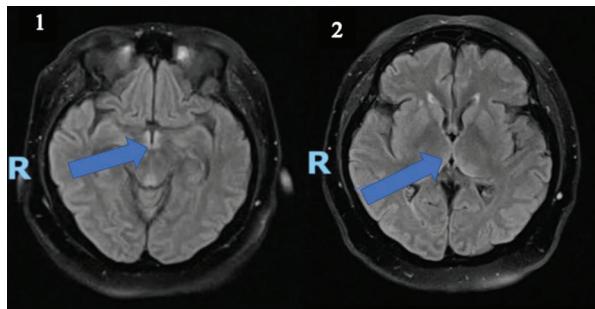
La flecha en la imagen 1 señala la hiperintensidad de tálamo y la flecha en la imagen 2 señala la hiperintensidad de los ganglios basales. Se observa una hiperintensidad en secuencias T2 y FLAIR, en la región anterior y lateral a la cabeza del núcleo caudado, sin restricción a la difusión, en relación con cambios por microangiopatía.
